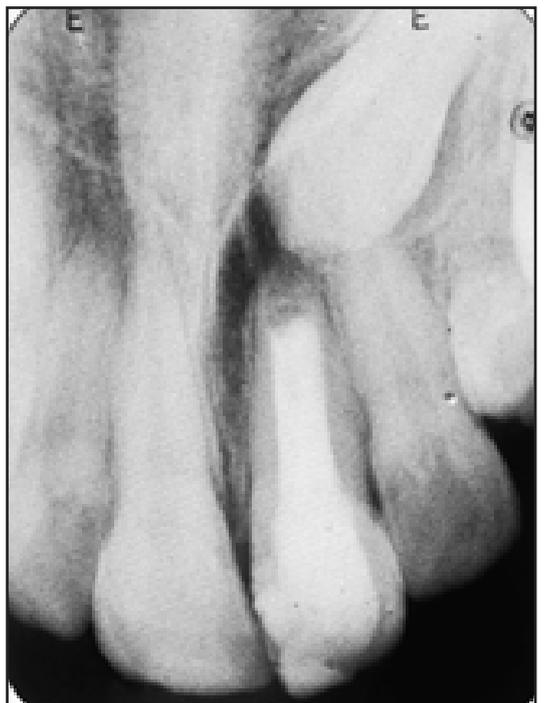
A radiograph showing apical root formation after 3-years follow-up.
